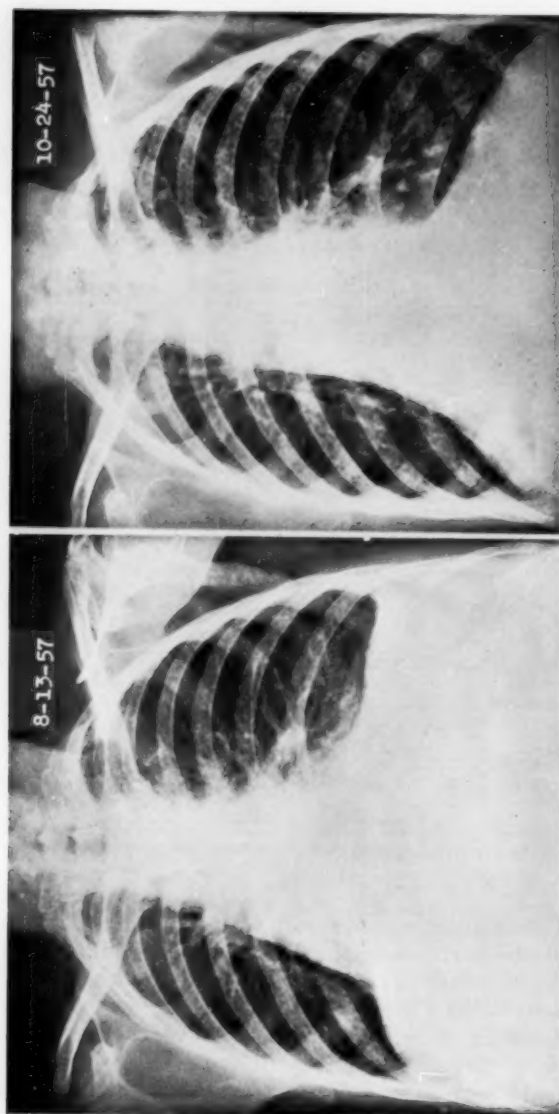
X-rays of lungs before and 10 weeks after operation in Case 9.
